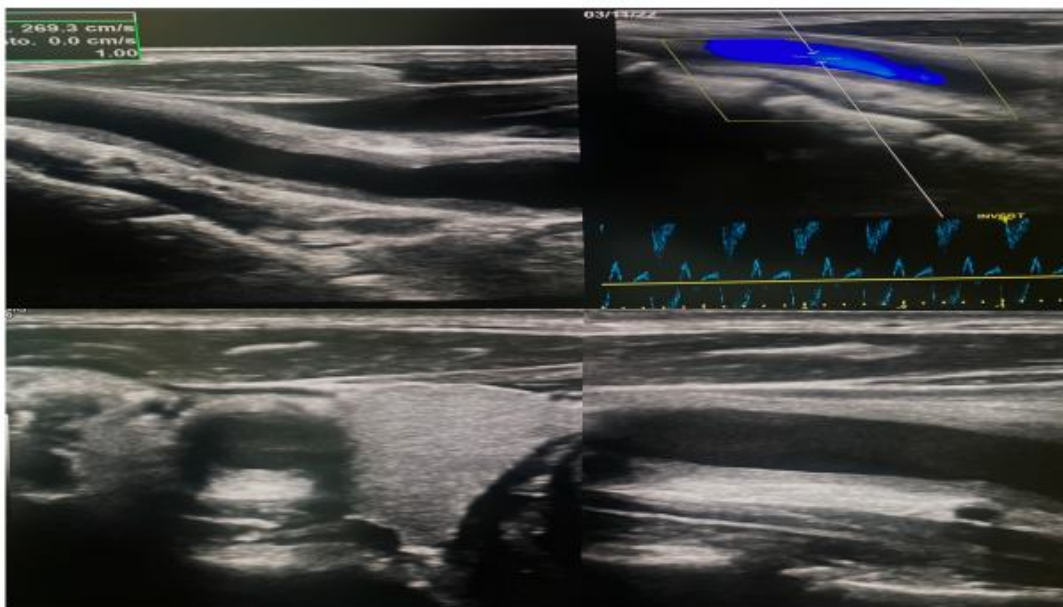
Ultrasound of the supra aortic trunks showing a halo aspect.
